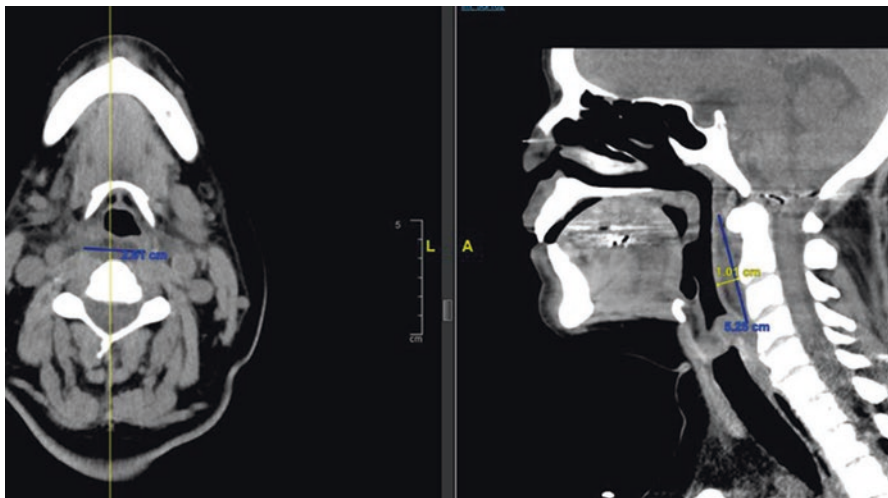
CT of the neck of a patient with C3-C4 prevertebral abscess
